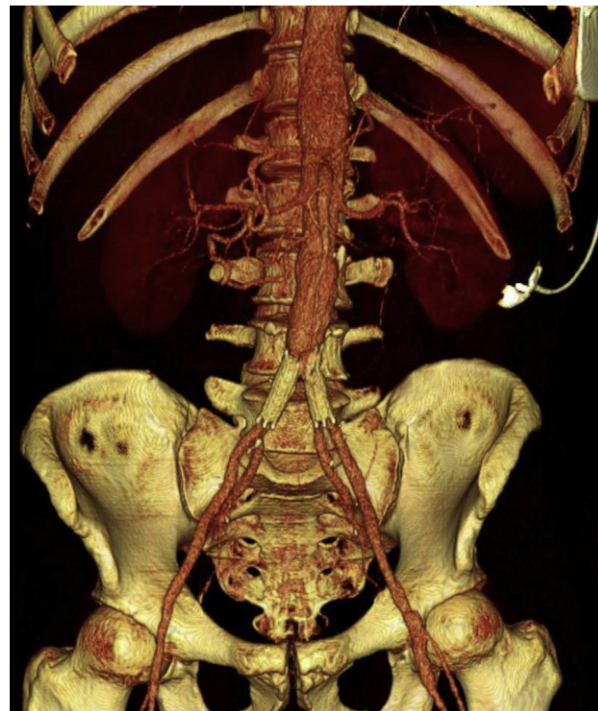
The 30-day postoperative CTA confirmed the technical success of the treatment.
